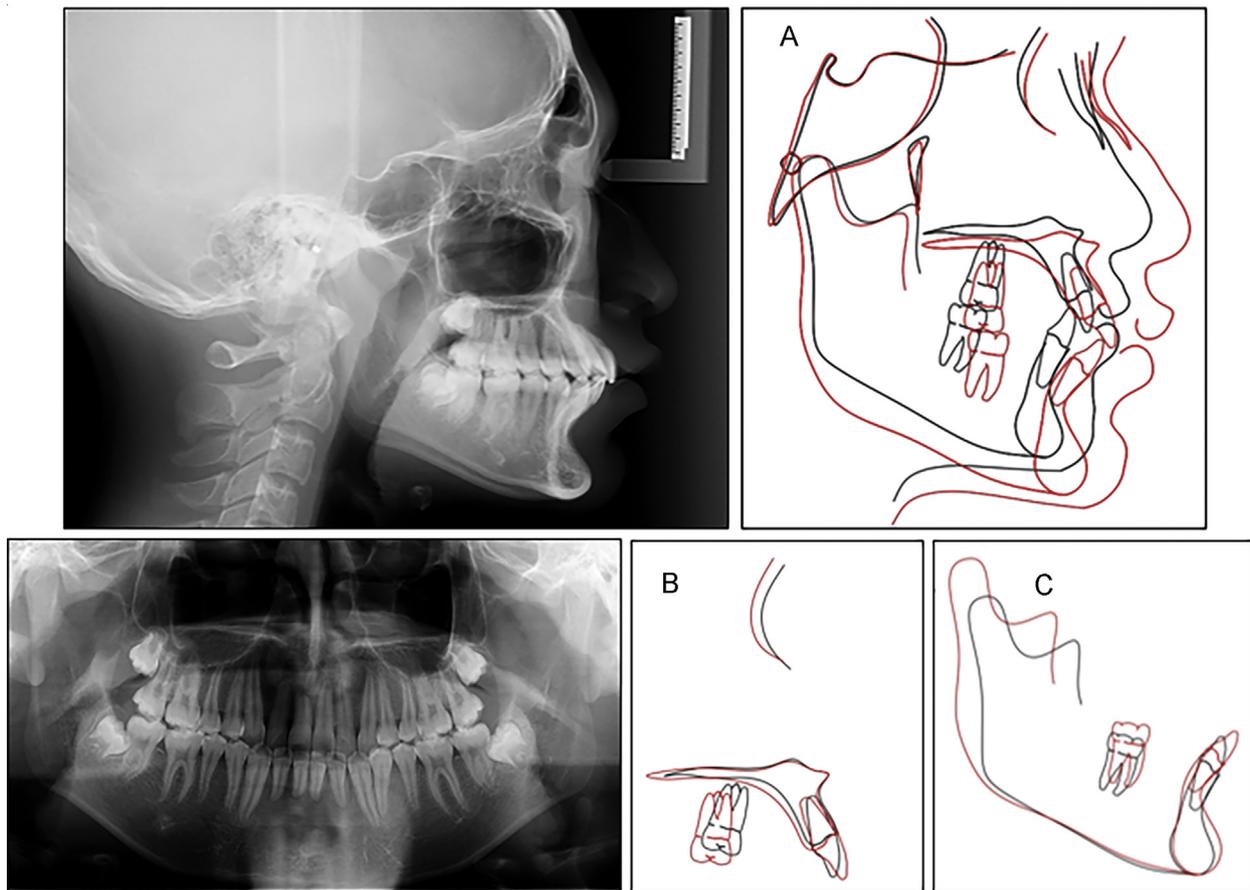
Posttreatment radiographs and cephalometric superimposition (black lines: before treatment; red lines: after treatment).
